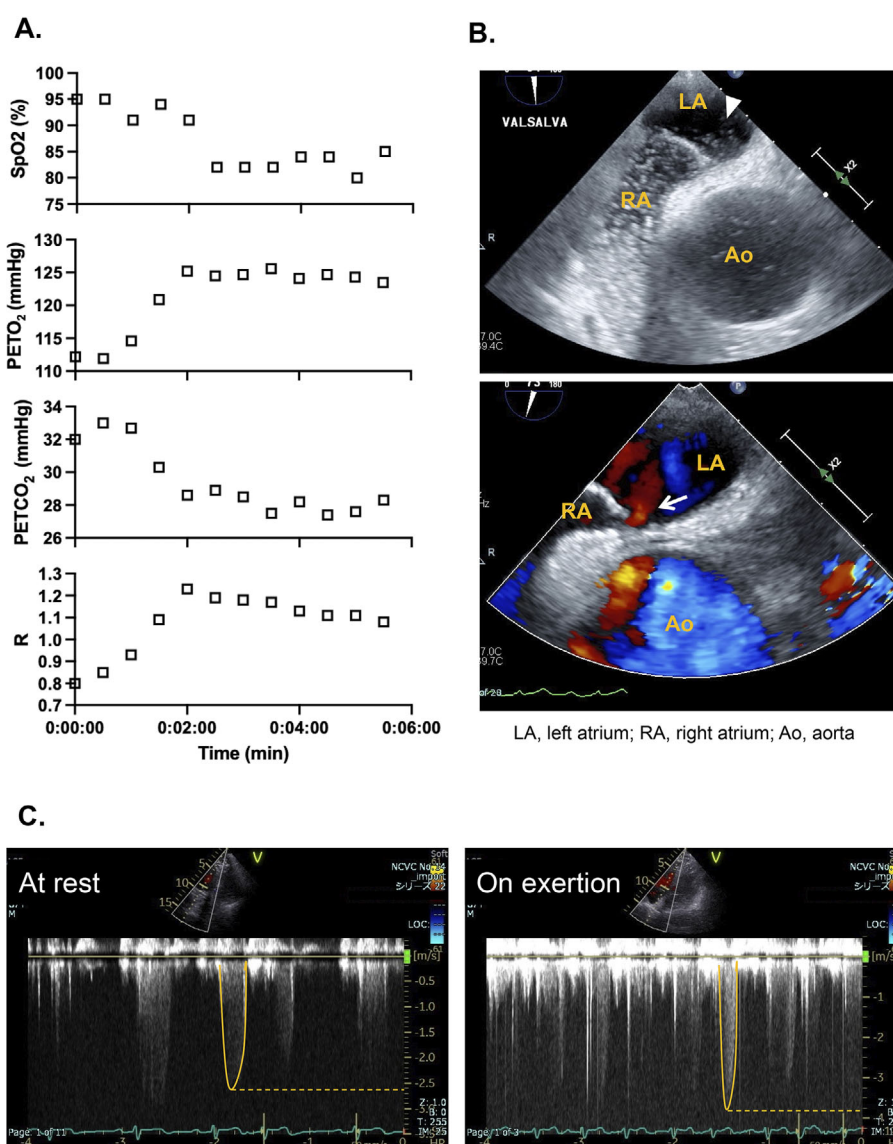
(A) Temporal changes in SpO₂ (%), PETO₂ (mmHg), PETCO₂ (mmHg), and respiratory exchange ratio. The test was terminated at 5 minutes and 38 seconds due to dyspnea. The Borg rating of perceived exertion scale score was 5 at the time of termination. (B) TEE images obtained during the bubble test (upper). Bubbles filled the RA and were also observed in the LA, suggesting that bubbles produced in the RA flowed into the LA via the PFO. TEE color Doppler images (lower) showing blood flow from the RA into the LA (arrow). At rest, TRV was approximately 2.6 m/s, and TRPG was calculated as 27 mmHg. On exertion, TRV was approximately 3.8 m/s, and TRPG was calculated as 58 mmHg. LA: left atrium, PETCO₂: partial pressure of end-tidal carbon dioxide, PETO₂: partial pressure of end-tidal oxygen, PFO: patent foramen ovale, R: respiratory exchange ratio, RA: right atrium, SpO₂: percutaneous oxygen saturation, TEE: transesophageal echocardiography, TRPG: tricuspid regurgitation pressure gradient, TRV: tricuspid regurgitation velocity, Ao: aorta
